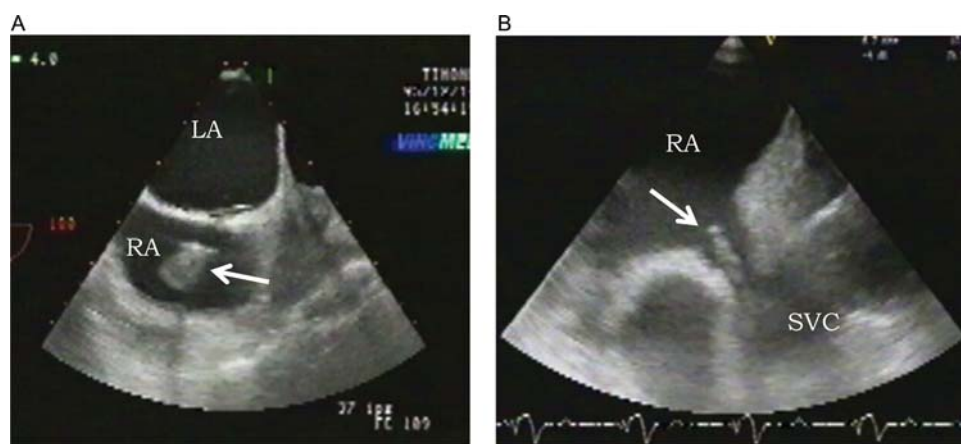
Pacemaker lead infective endocarditis (transoesophageal echocardiography). (A) Typical vegetation on a pacemaker lead (arrow). (B) Thickening of the pacemaker lead with a sleeve-like appearance (arrow). RA, right atrium; LA, left atrium; SVC, superior vena cava.
